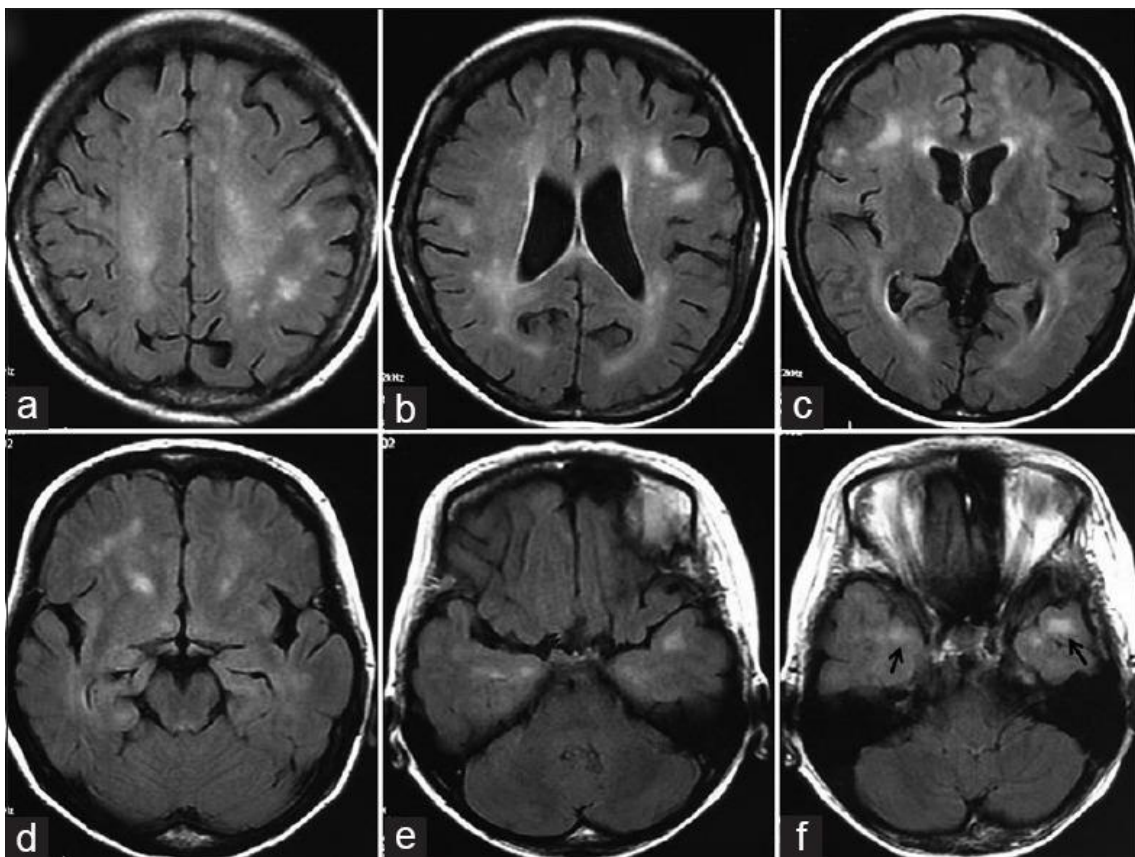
The axial brain magnetic resonance images in a patient with MD1. (a-d) White matter hyperintense lesions in both subcortical and periventricular areas, single or confluent; (e-f) Areas of high signal in the subcortical white matter of the anterior temporal lobes (arrows) [291].
